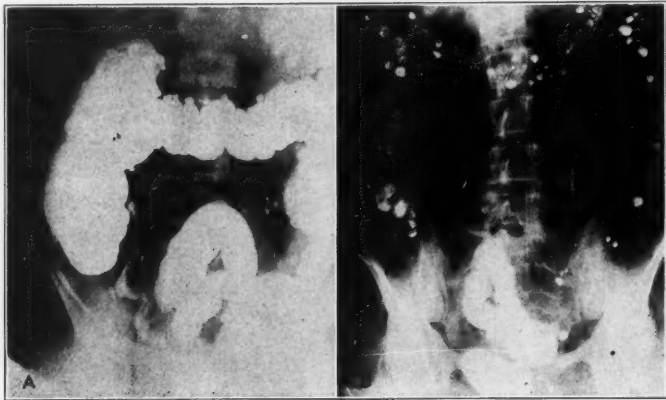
(A) A case of diverticulosis. Note the diverticula along the entire course of the colon. (B) Roentgenogram of a typical colon twenty-four hours after the administration of barium, showing many diverticula.
